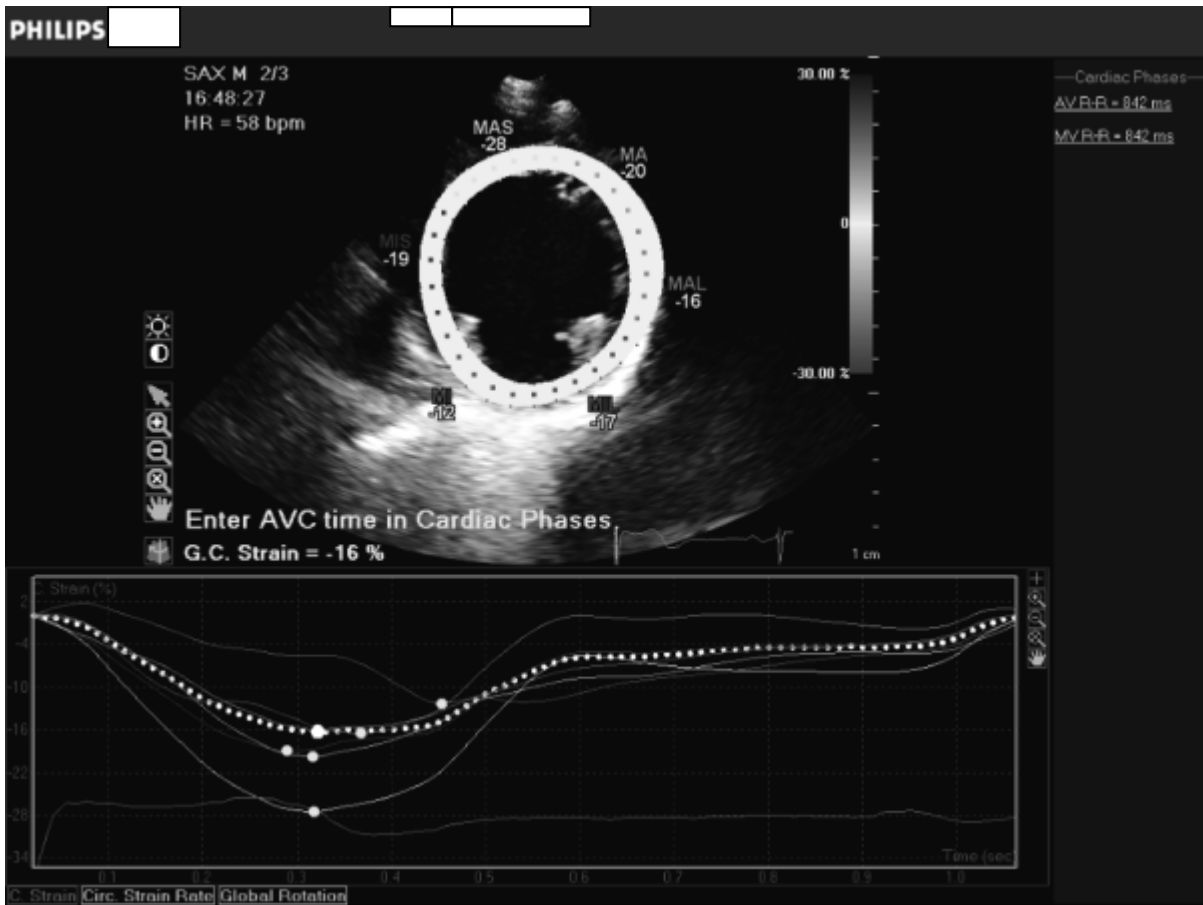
Parasternal short axis view at papillary muscle level for global circumferential strain
